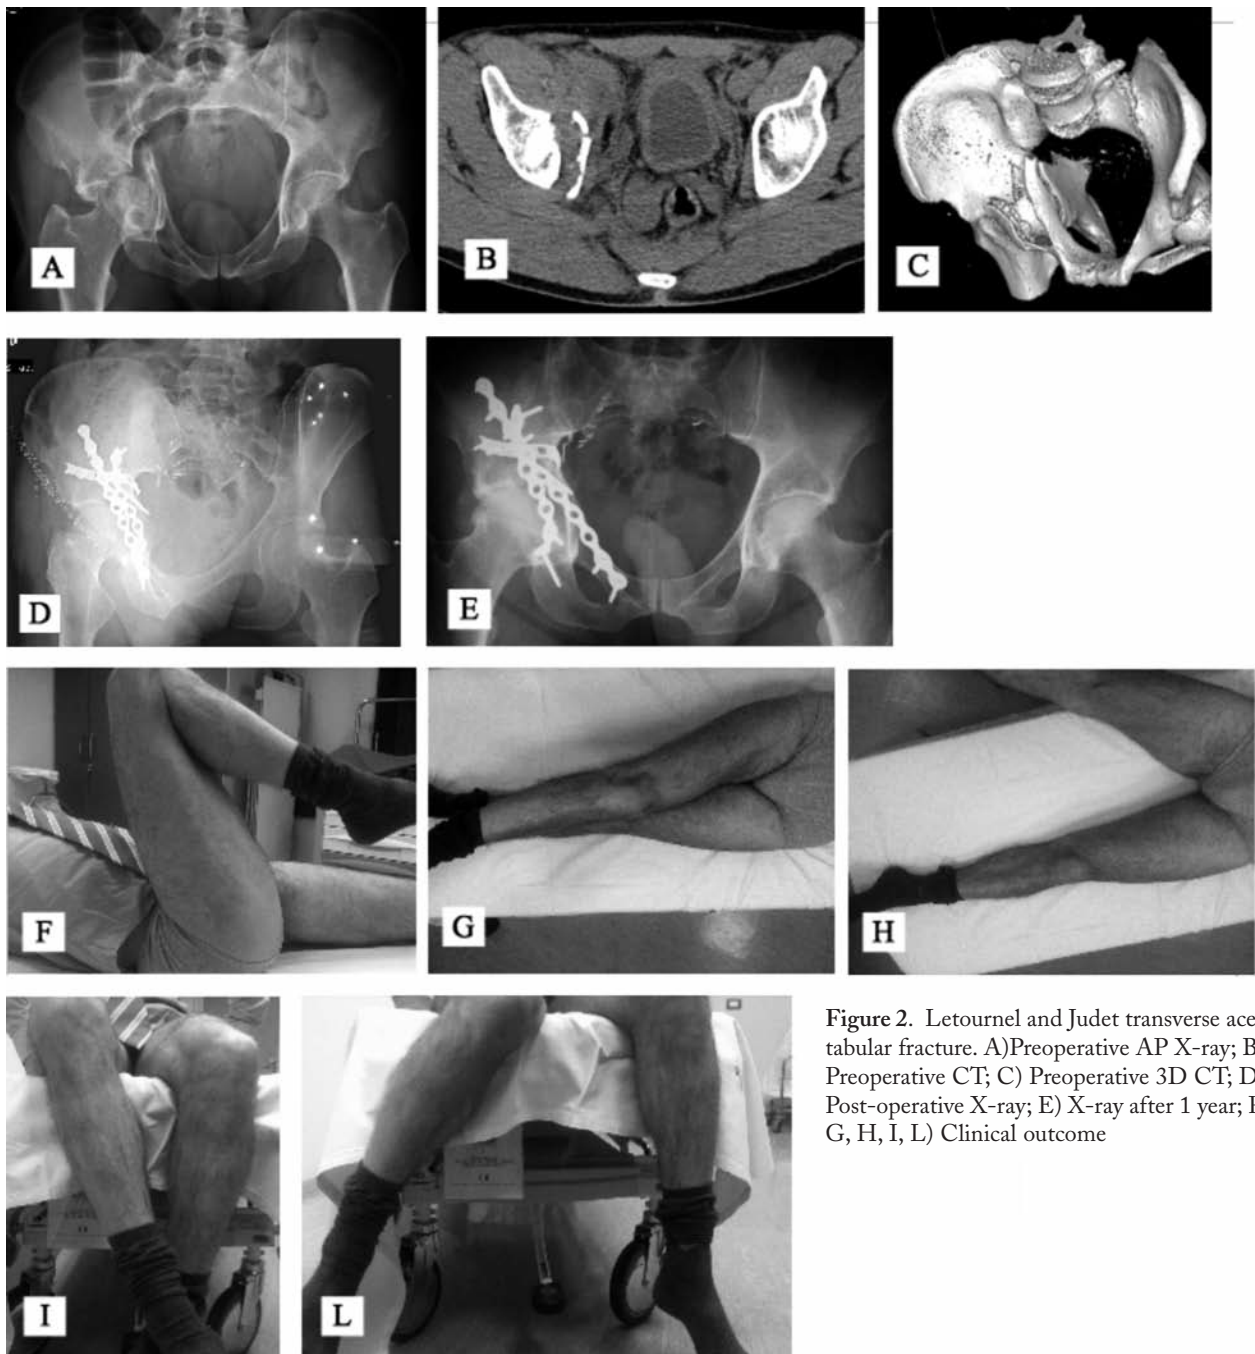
Letournel and Judet transverse acetabular fracture. A) Preoperative AP X-ray; B) Preoperative CT; C) Preoperative 3D CT; D) Post-operative X-ray; E) X-ray after 1 year; F, G, H, I, L) Clinical outcome
